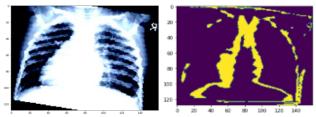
Down sampled radiograph of a pneumonia -afflicted chest (left) and segmentation through proposed method (right).
